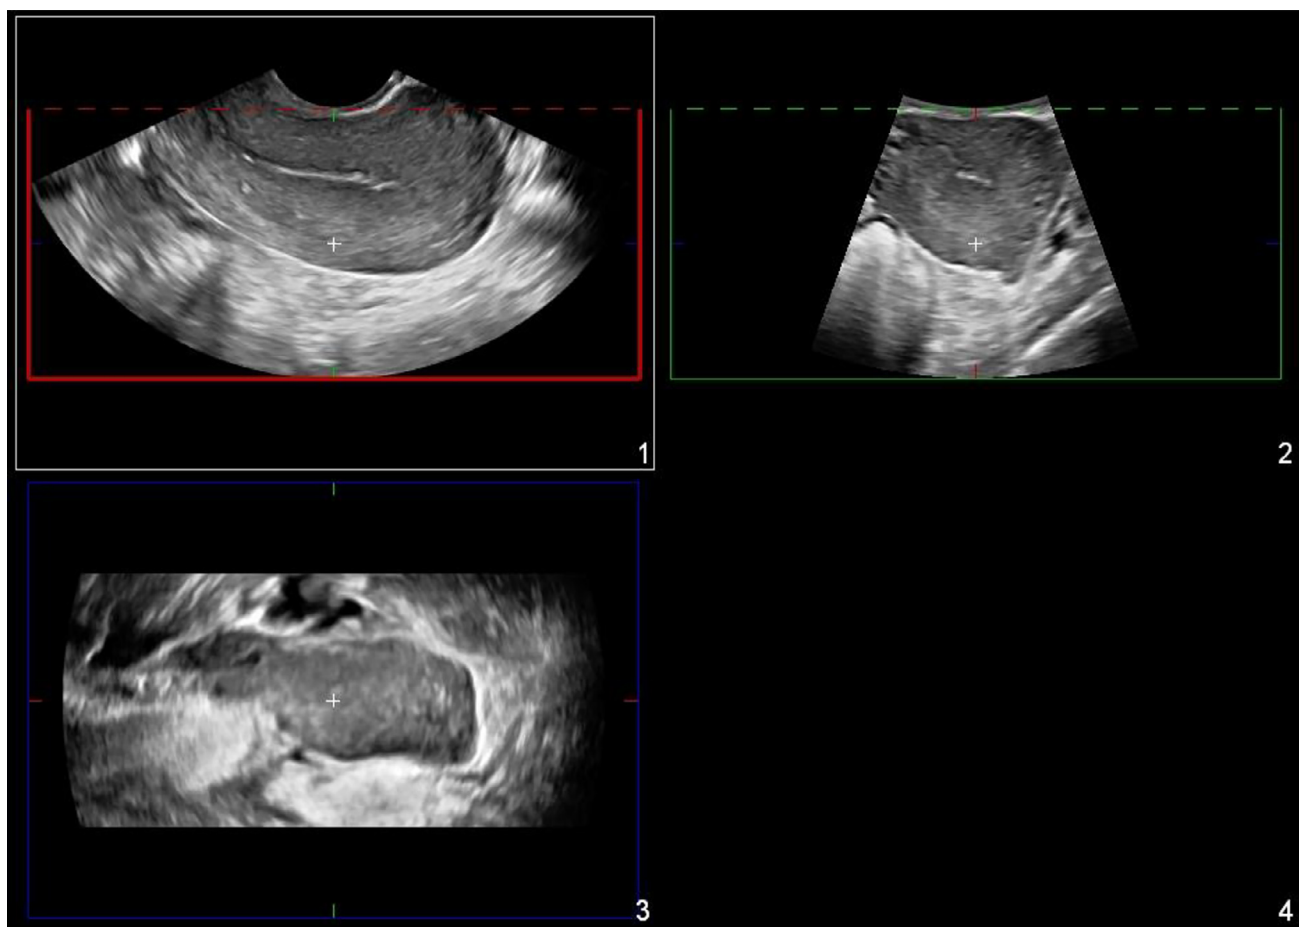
Three-dimensional reformatted ultrasound images of uterus without intrauterine device identified. Further evaluation with abdominal radiograph was recommended.
